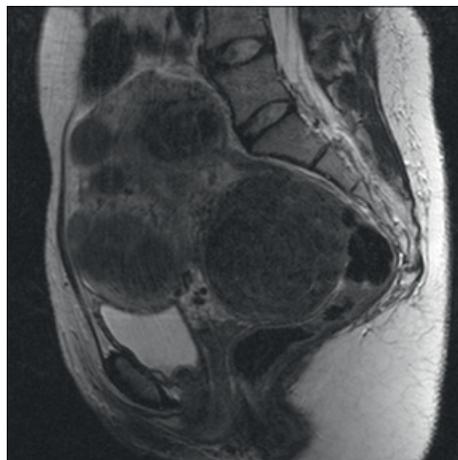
MRI image demonstrating an enlarged uterus with multiple fibroids.
